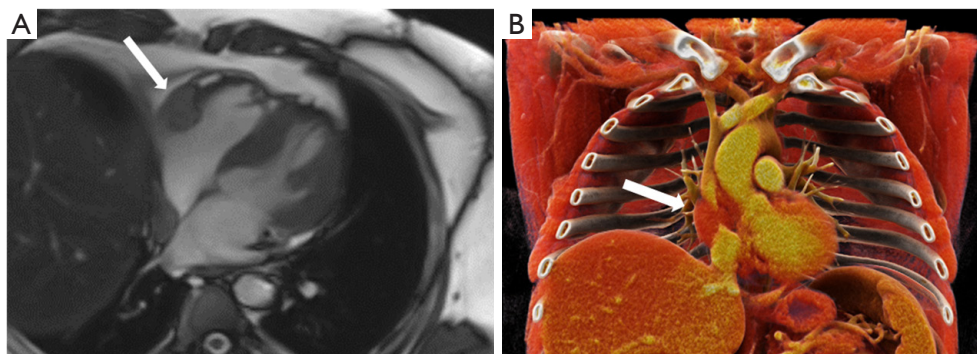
Cardiac involvement in Erdheim-Chester disease (ECD). (A) 4 chamber view of cardiac MRI showing a solid mass in right atrio-ventricular sulcus (white arrow); (B) 3D Cinematic Rendering of dual source computed tomography (DSCT) acquisition (white arrow).
